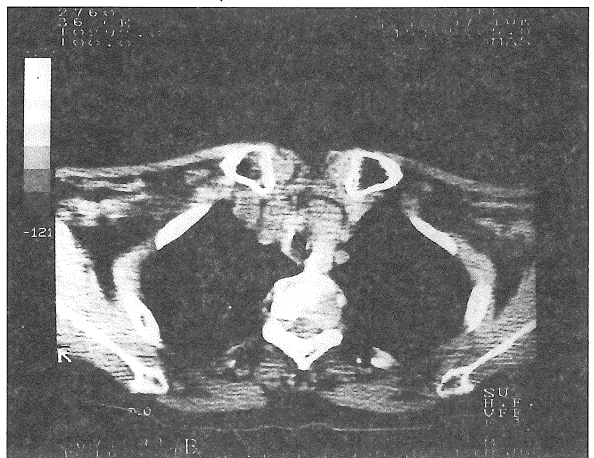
CT scan showing tracheal obstruction from tumour which has also invaded the T3 vertebra
